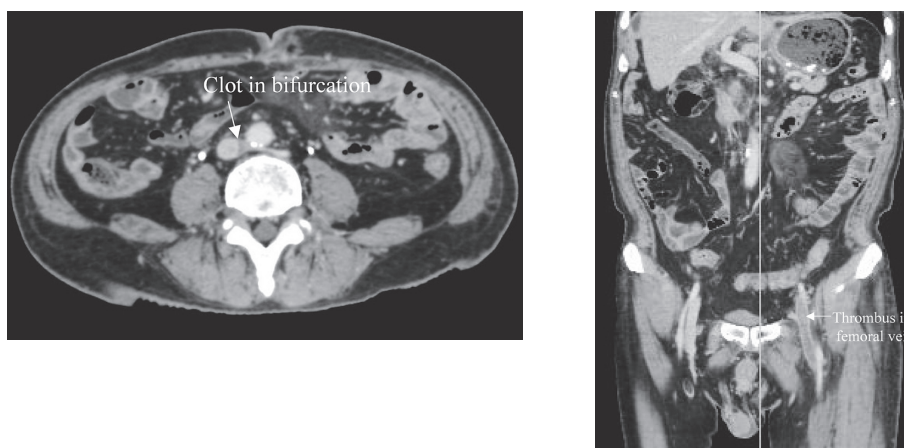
An abdominopelvic CT image revealed a massive amount of thrombus in the left iliofemoral vein, and this thrombus closed to the periphery of the vascular bifurcation.
